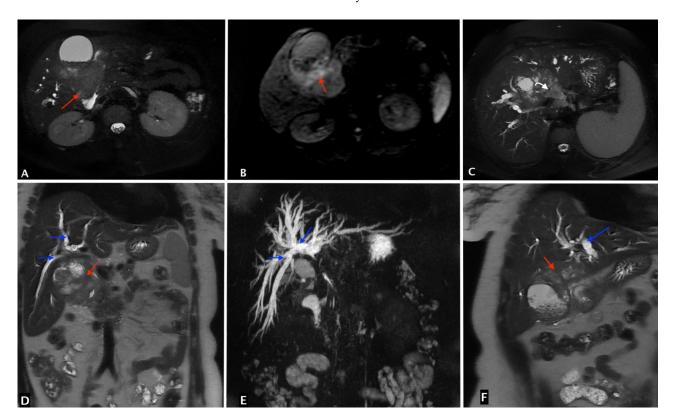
Biliary MRI: Sequences of an axial T2 FAT SAT liver MRI (A,C), axial diffusion b 800 (B), coronal T2 without FAT SAT (D,F), and coronal 3D biliary sequence (E) with 5 mm Scale Bar showing a distended gallbladder with tissue thickening in the lower part, with T2 hyposignal and diffusion hypersignal (red arrows), encompassing the hepatic hilum and the VBP (white arrow) and causing dilation of the VBIH (blue arrows). Note the gallbladder microlithiasis in the image (F).
